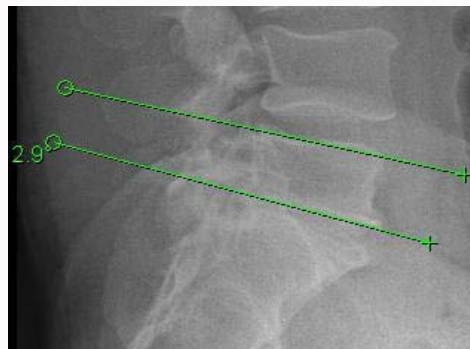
Lateral radiographs of lumbar spine with the vertebral kyphosis angle.
